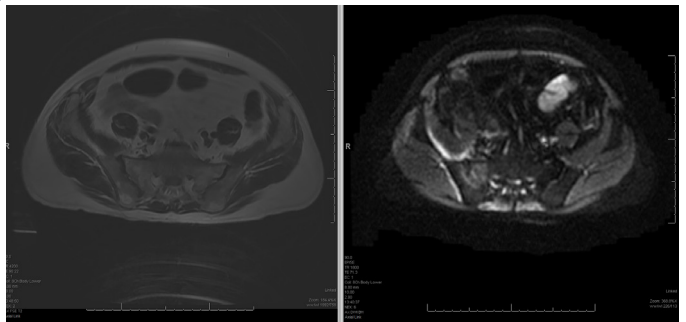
MRI imaging with T2 FSE (Left) and DWI High B value (Right) images showing hyperintensity at SI joint as well as beneath the iliacus on DWI images.
